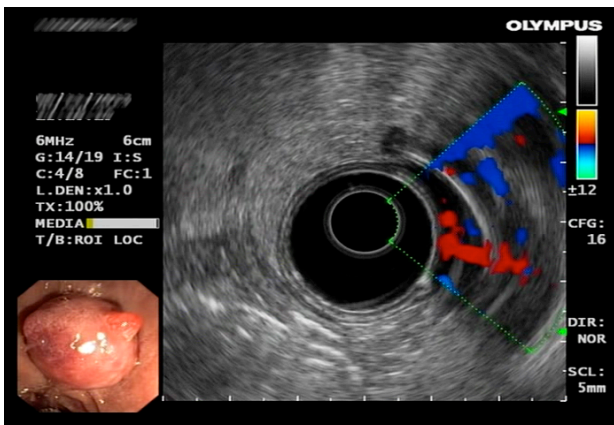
EUS – Doppler examination
